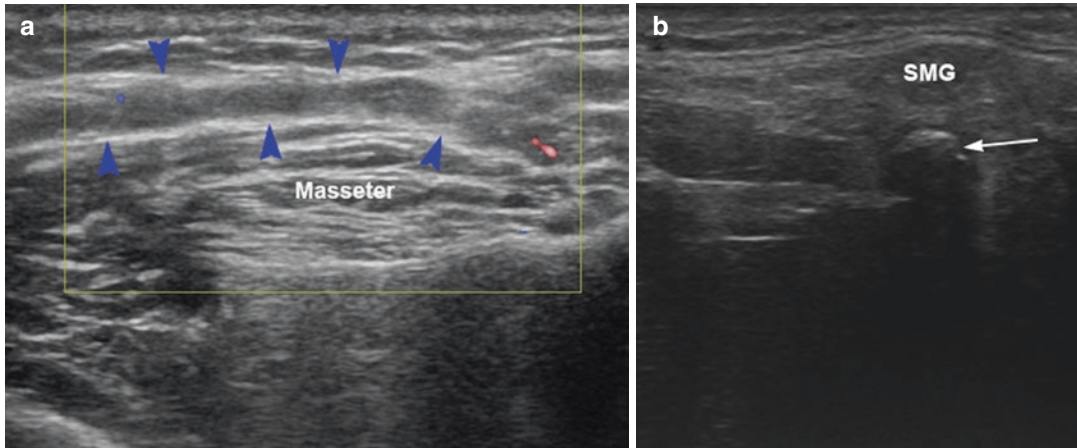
Ultrasound of the left anterior cheek (a) demonstrates a dilated main parotid duct (*blue arrowheads*) over the masseter muscle due to distal stenosis at the papilla. The lack of Doppler flow within the hypoechoic tubular
